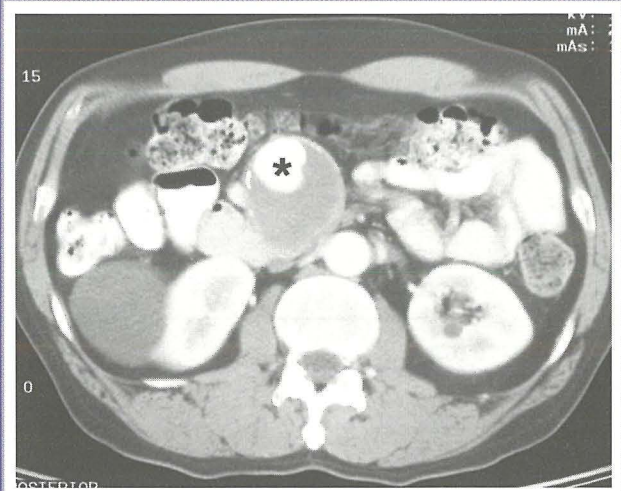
Contrast-enhanced CT scan shows a superior mesenteric artery aneurysm with an enhancing lumen (*) surrounded by mural thrombus mimicking a primary pancreatic lesion
